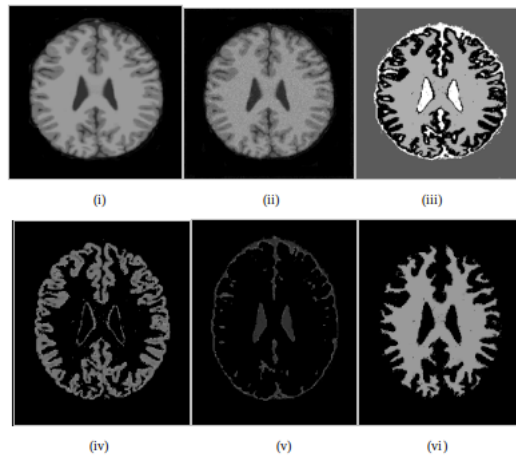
(i) MRI T1-99, (ii) MRI with 5% noise, (iii) MRI segmented using ACO-FCM, (iv) MRI with Gray, (v) CSF, (vi) MRI with White
